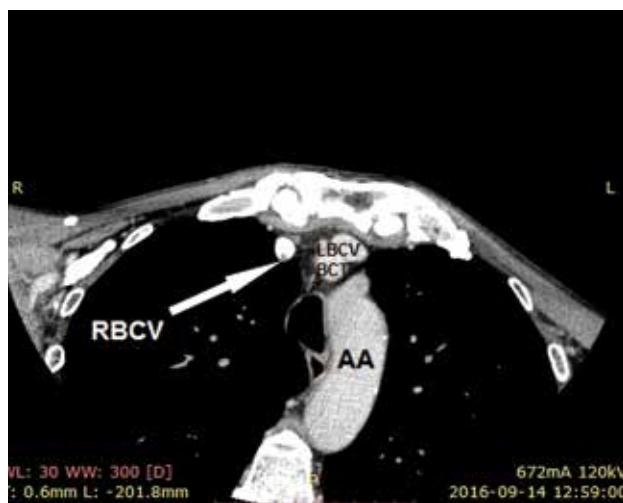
Computed Tomography Angiography (CTA) showing (arrow) a small defect filled with calcification in the right brachiocephalic vein (RBCV). Left brachiocephalic vein (LBCV), brachiocephalic trunk (BCT), arcus of aortae (AA)
